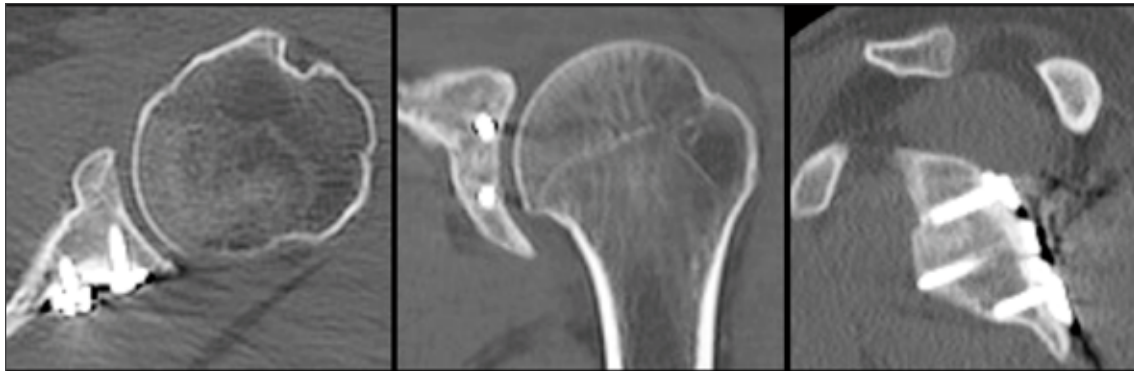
Postoperative 2D CT reconstruction of the glenoid.
